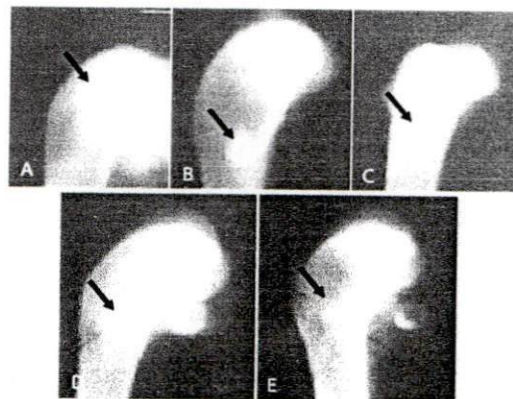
X-ray images of the extracted femurs: (a) After 2 days, a circle image of homogeneous density is observed, which is similar to the implant (black arrow), (b) After 1 week implantation, the image shows full circle, (c) After 2 weeks, gradually the image shows minimize; (d) After 3 weeks, the circle image is smaller than 2 weeks and (e) After 4 weeks, the circle image is smallest, and the implant component union with hostbone.
